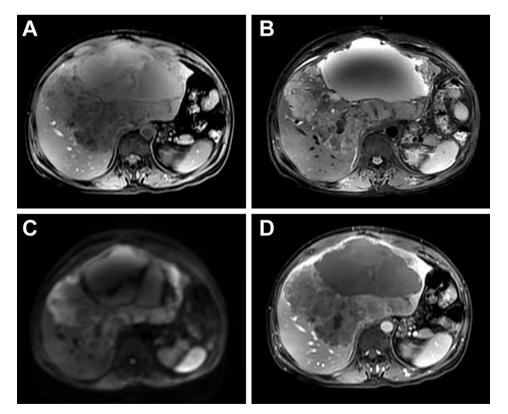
A large, well-defined, lobulated mixed cystic and solid lesion occupying both lobes of the liver showed hypointensity on T1-weighted imaging (A), hyperintensity on T2-weighted imaging (B), and diffusion-weighted imaging (C). During dynamic study, the lesion revealed poor contrast enhancement (D).
